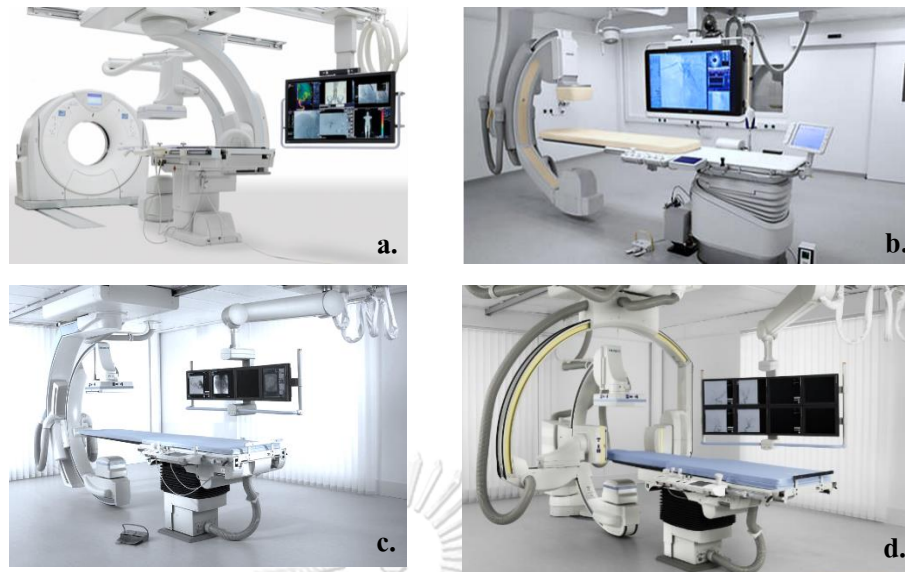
8 Angiographic equipment a. Canon (Toshiba) hybrid angiography CT system model Infinix-i 4D CT, b. Philips biplane fluoroscopy model Allura Clarity Xper FD20/15®, c. Siemens single plane fluoroscopy model Artis zee with PURE®, d. Siemens biplane
